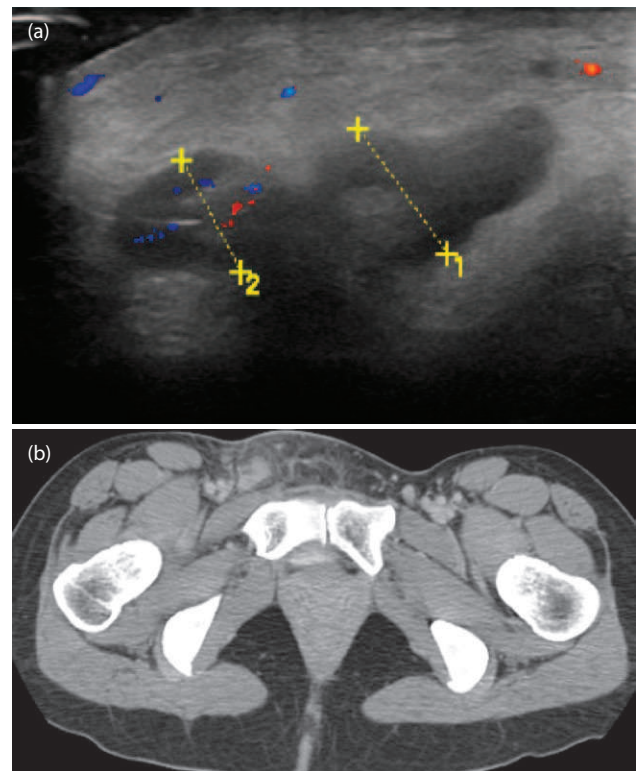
(a) Ultrasonography (US) and (b) computed tomography (CT) showed radiographic features of inguinal lymphadenitis.
